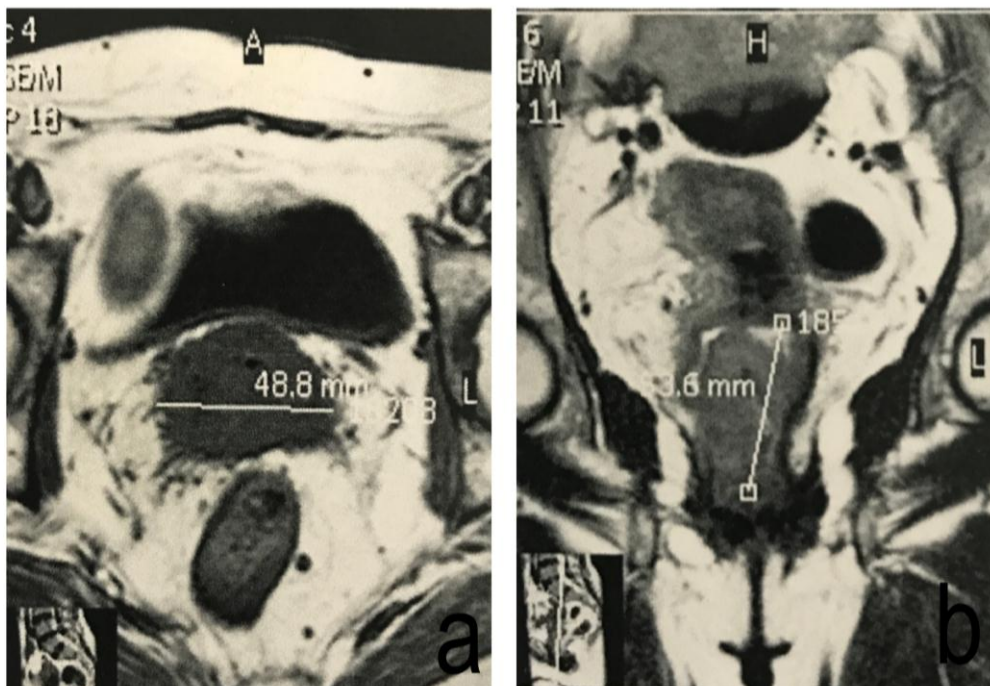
Axial (a) and coronal (b) T2W magnetic resonance imaging showing hyperintense mass replacing uterine cervix infiltrating the vaginal fornices and extending to lower third of the vagina (stage III A).
